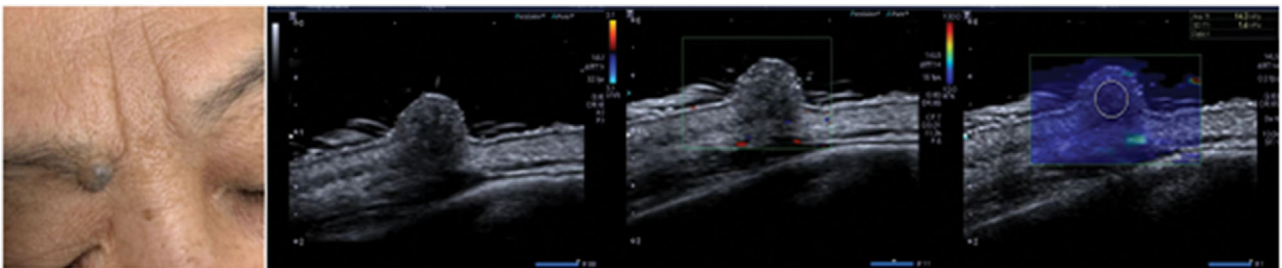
2D, Doppler, and SWE images of pigmented nevus
